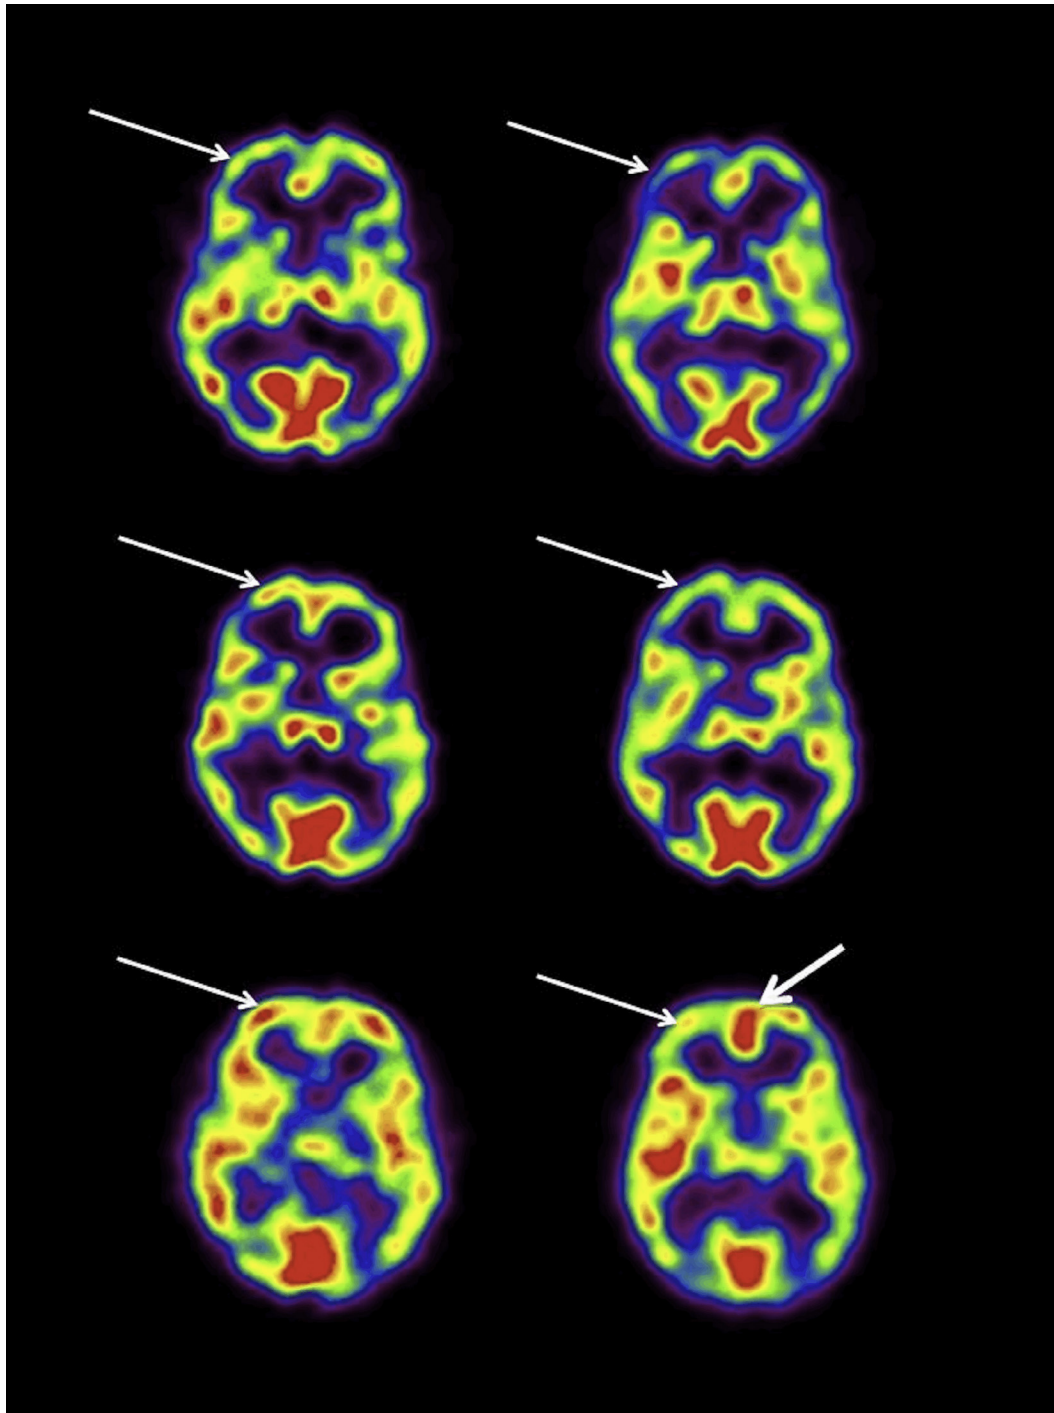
Transaxial SPECT scan results from each of the participants performing intense Islamic prayer practices (CBF ranges from high to low as demonstrated by the colors red > yellow > green > blue > black). The scans in the left column show the resting scan in the first two Sufi practitioners (first two rows) and the automatic salat practice of the third subject. The scans in the right column show the CBF pattern during intense Islamic prayer for the Dhikr in the two Sufi practitioners and the more intense form of salat in the third individual. The scans demonstrate general decreased frontal lobe activity (thin arrow) in all three participants during intense prayer. The individual performing salat also showed increased activity in the anterior cingulate gyrus (thick arrow).
